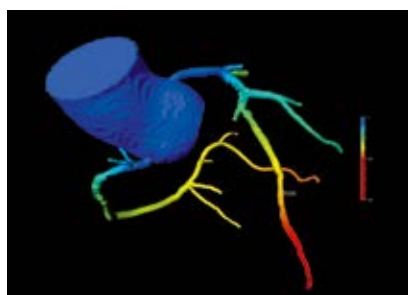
CT-based fractional flow reserve (cFFR) colour with cFFR = 0.82 in the LAD. The point of cFFR evaluation is freely adjustable.
